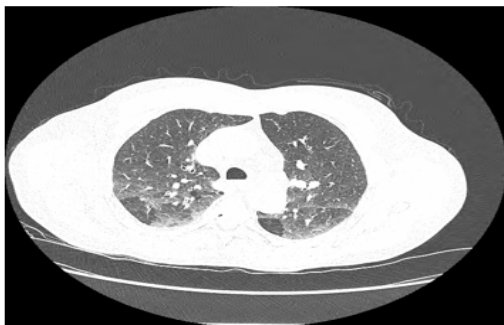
Injected chest CT scan: Mosaic attenuation with significant trapping was shown on the expiration CT, suggestive of HP
